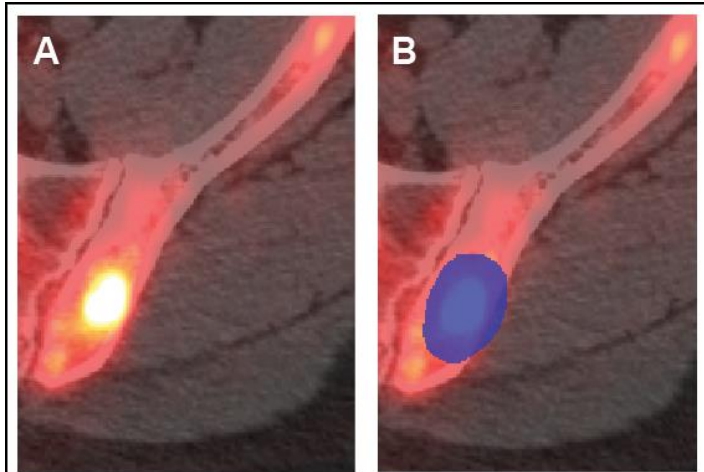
SBRT as metastasis directed treatment for oligometastatic prostate cancer. A. NaF PET-CT fused to diagnostic CT scan reveals a hyper metabolic focus in the left ilium corresponding to an underlying sclerotic lesion. B. Isodose distribution of ablative, single fraction SBRT to a dose of 20 Gy. Note the coverage of the PET positive focus and areas of bony sclerosis with simultaneous sparing of adjacent normal structures.
